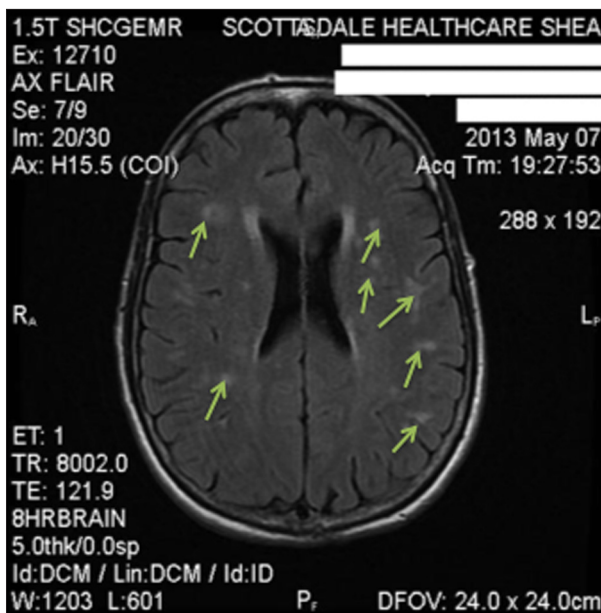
Brain MRI showing multiple intracranial masses compatible with metastatic disease.
